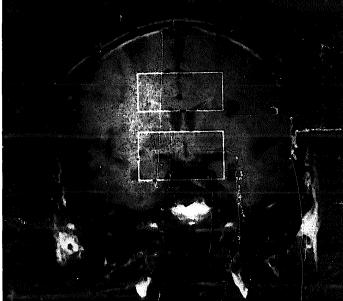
Top: midsagittal MRI showing region A (1) and region B (2). Bottom: midcoronal MRI showing region A (1) and region B (2).
